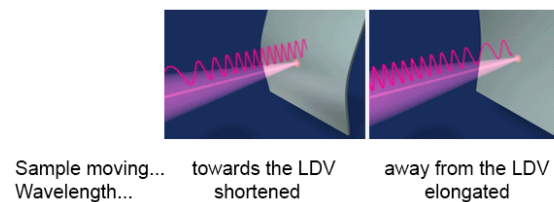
The motion of the sample adds a Doppler shift to the beam. The wavelength λ is shortened when the sample moves towards the laser head and elongated when it moves away from the laser head. Adapted from (Polytec_GmbH 2015b).
